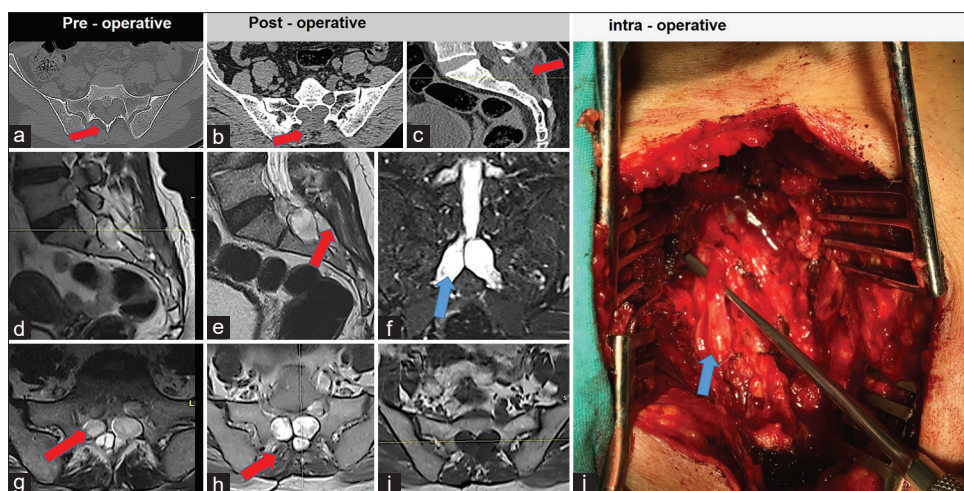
Preoperative, postoperative, and intraoperative images of the case. (a) The lamina that covered the posterior sacrum appeared to have been thinned in the preoperative axial computed tomography image. Foramina in the sacrum appeared to be regularly wider and greater than the normal, based on the diffuse growth of the nerve roots. (b and c) A mass was visible in the computed tomography image, extending from the neural foramina of the sacral spinal area into the presacral area. The pelvic computed tomography showed an occlusion defect toward posterior at the sacral level and large-scale expanded nodular mass lesions in the neural foramina. After the surgical decompression, the sacrum lamina was not observed in the area marked with red arrows. (e-j) in the postoperative magnetic resonance, a mass lesion was visible, extending from the neural foramina of the sacral spinal area into the presacral area. (d) A mass lesion was visible on the sagittal T2-magnetic resonance image. (e) On the sagittal T2-magnetic resonance image, a mass extending from the neural foramina of the sacral spinal area to the presacral area was visible, which was expanding toward the posterior and upwardly following the surgery. (f) In the turbo-spin-echo sequence, the lumbar spinal S1 root appeared to be quite large. (g) The right S2 sacral spinal nerve root was visible on the axial T2-magnetic resonance image section. (h) After the removal of sacrum lamina, the sacral nerve roots appeared to have shifted posteriorly. Because a piece of the S2 nerve root was extracted to get the true diagnosis, the right S2 nerve root was not visible. (i) The lesion appeared to have no contrast on the contrast-enhanced T1-magnetic resonance image section. (j) In surgical view, the right S2 nerve root appeared to have diffusely grown in every direction
